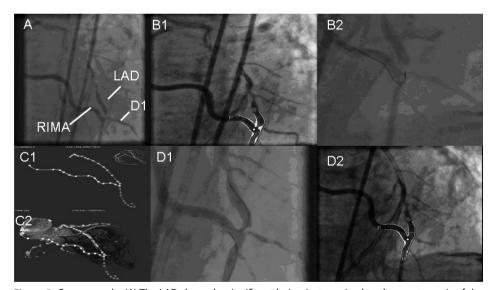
Case example. (A) The LAD showed a significant lesion just proximal to the anastomosis of the LIMA graft (bifurcation lesion (0,0,1) with the ramus diagonalis). (B1) The QCA pre-stent implantation revealed a diameter stenosis of 64% in the side branch (minimal luminal diameter 0.89mm; reference diameter 2.48mm). (B2) Magnetic vectors are used to steer guidewire. (C1) Multislice CT can be utilized to create a vessel road map. (C2) Three-dimensional reconstruction. (D1) Guidewire through ostial lesion (provisional stenting technique). (D2) The QCA post-stent implantation (Xience V 3x8mm), showed a 9% diameter stenosis in the side branch (minimal luminal diameter 2.09mm; reference diameter 2.30mm). See this figue in color in the Appendix page 399.
